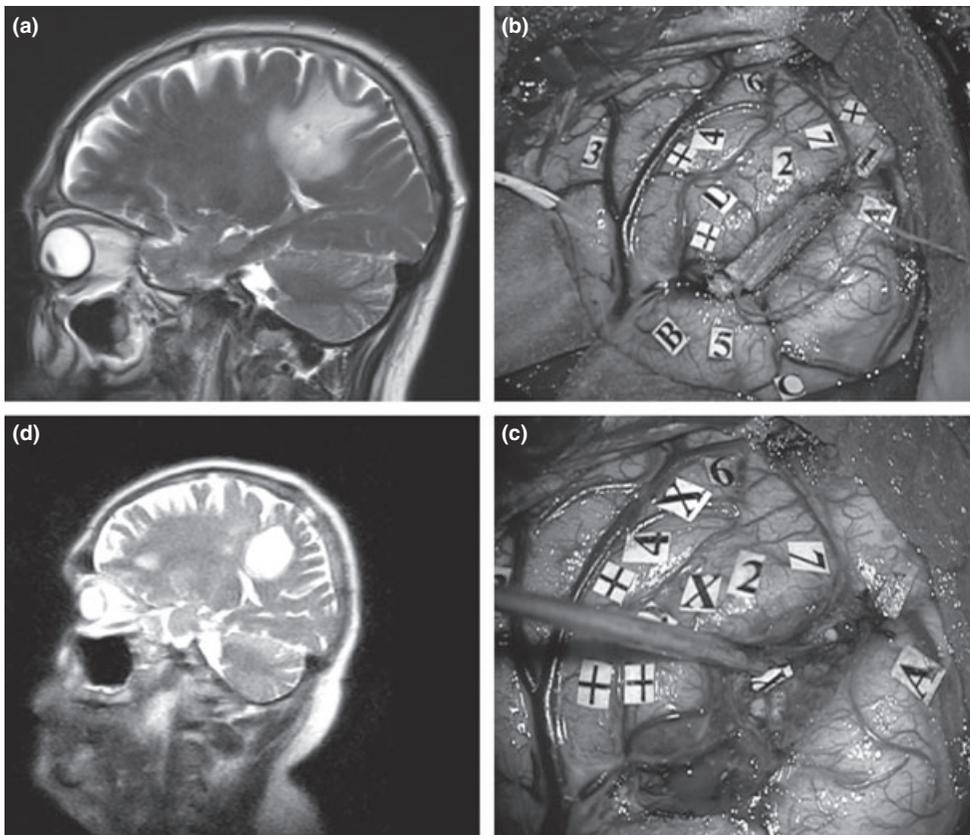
Pre-operative images showed a left parietal tumour in sagittal flair-weighted MRI sequences (a). Intraoperative view (b and c): the tumour is delineated by the letter tags. A cottonoid was placed in the portion of the Intra-Parietal Sulcus that resulted functional for calculation and consequently spared. Tags were placed corresponding to somato-sensory area (tag 1), speech arrest site (tag 2), naming interfering sites (tags 3–7), addition interfering sites (tags +), multiplication interfering sites (tags x; b). Tag x in the bottom of the Intra-Parietal Sulcus corresponding to the site which was functional for multiplication. Post-operative images (d) showed the surgical cave boundaries in sagittal flair-weighted MRI sequences.
